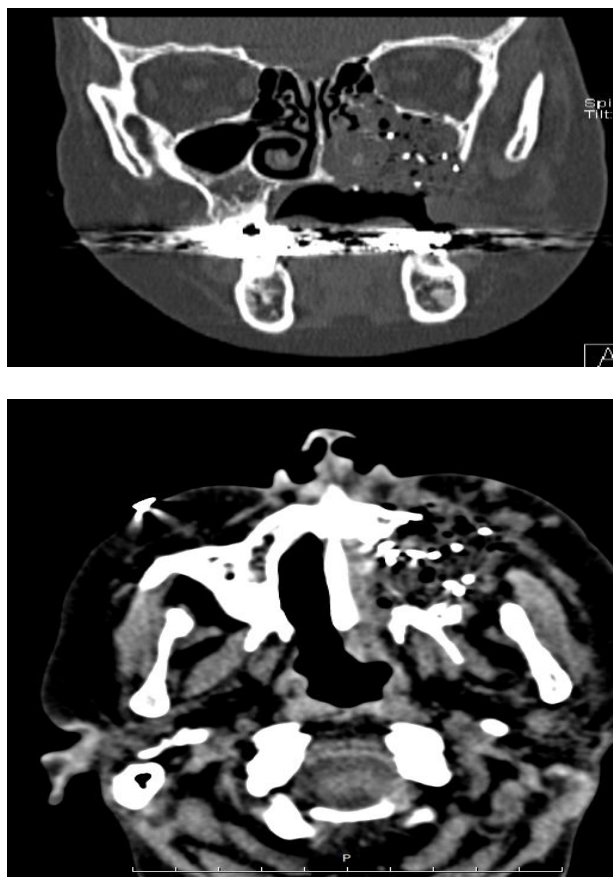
Paranasal sinus CT Scan post operation: Resection of lower and medial wall of maxilla and alveolar process.
